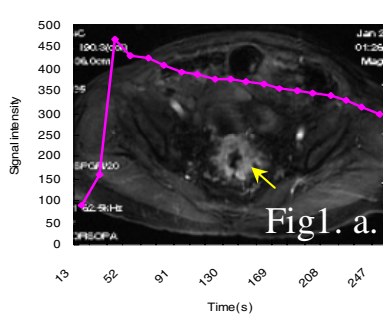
a) Arterial phase DCE-MRI shows rectal CA (arrow) with type A TIC, b) IHC with CD34 shows high MVD and c) strong VEGF expression.
